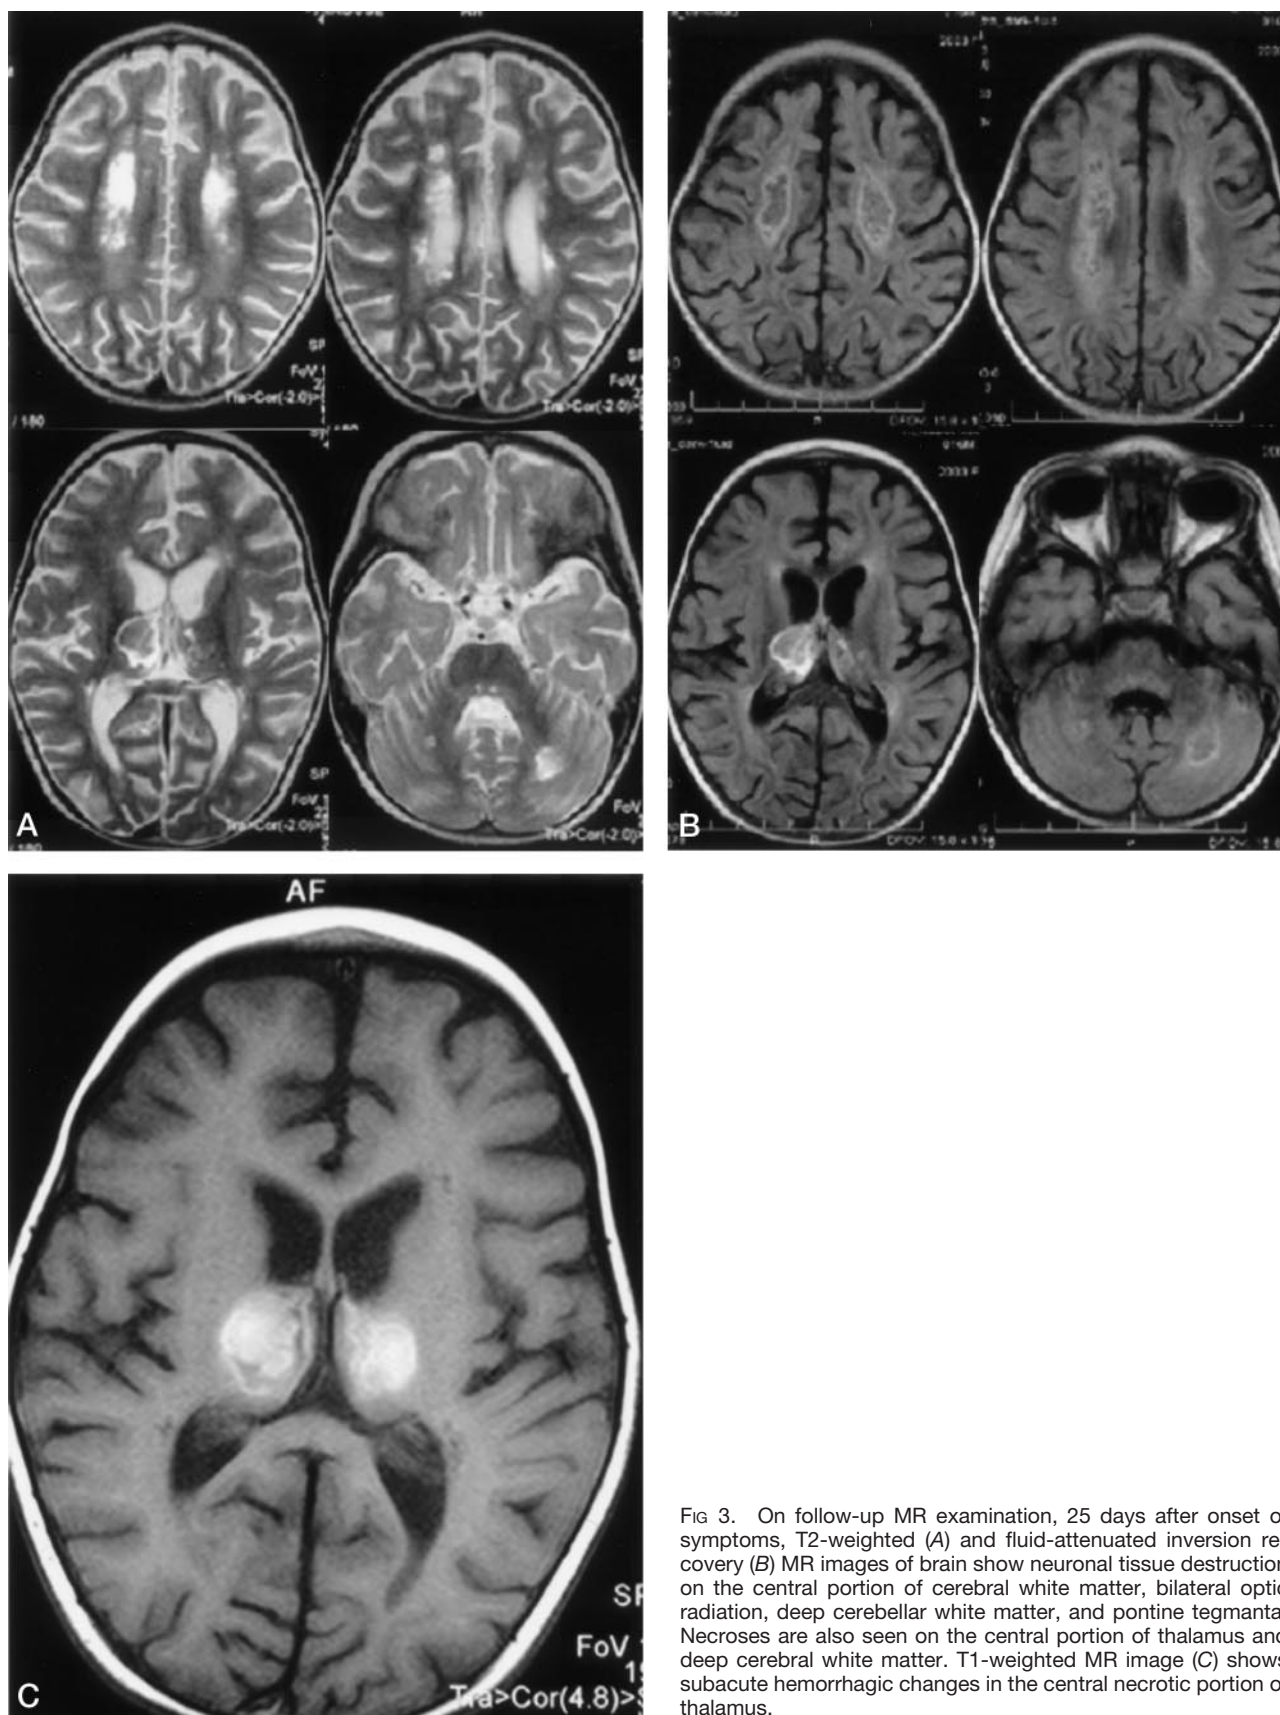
On follow-up MR examination, 25 days after onset of symptoms, T2-weighted (A) and fluid-attenuated inversion recovery (B) MR images of brain show neuronal tissue destruction on the central portion of cerebral white matter, bilateral optic radiation, deep cerebellar white matter, and pontine tegmenta. Necroses are also seen on the central portion of thalamus and deep cerebral white matter. T1-weighted MR image (C) shows subacute hemorrhagic changes in the central necrotic portion of thalamus.
